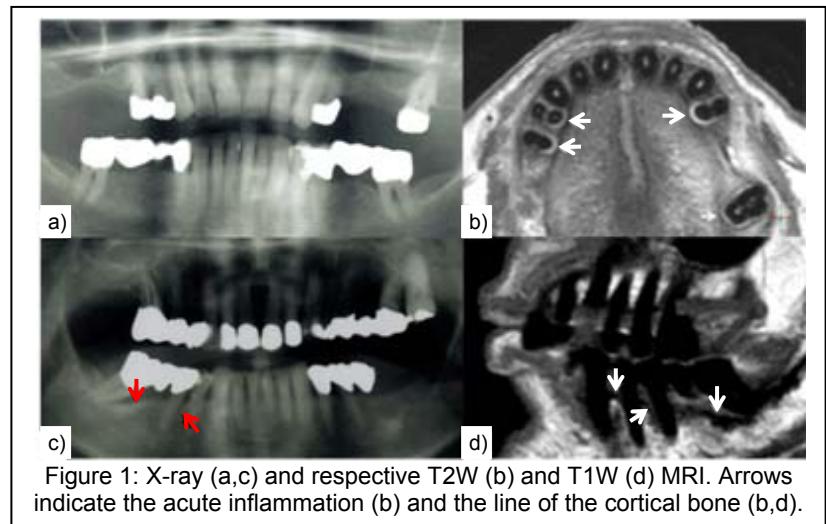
X-ray (a,c) and respective T2W (b) and T1W (d) MRI. Arrows indicate the acute inflammation (b) and the line of the cortical bone (b,d).
